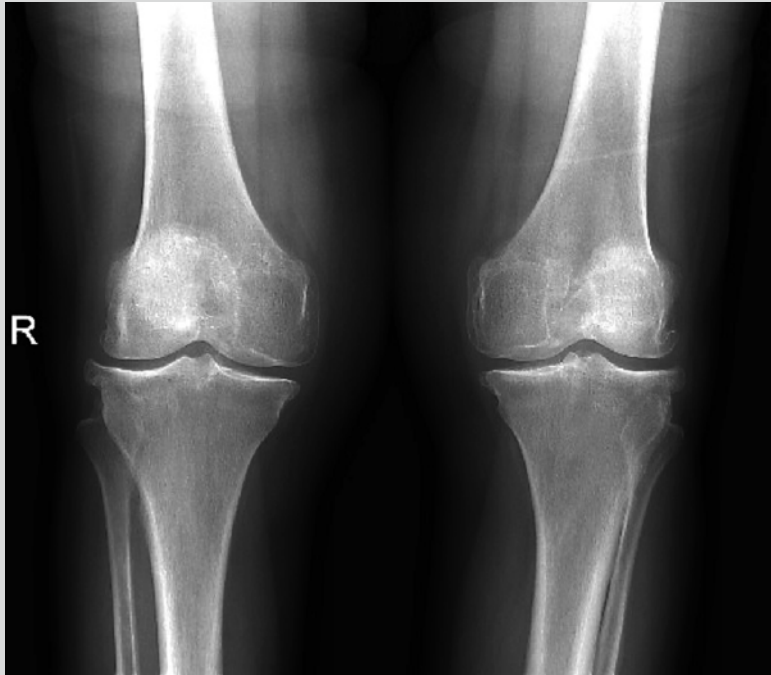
Bilateral standing X-ray of a 65-year-old female patient. Mild to moderate radiological findings of osteoarthritis were recognized
